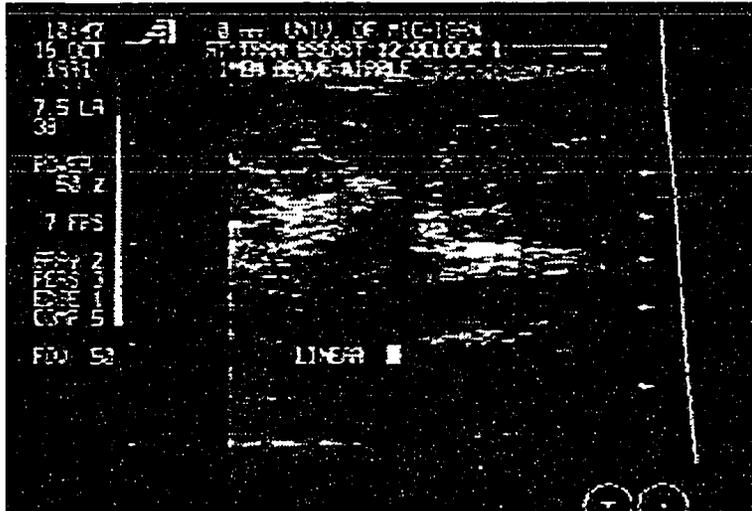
Ultrasound from patient B.
